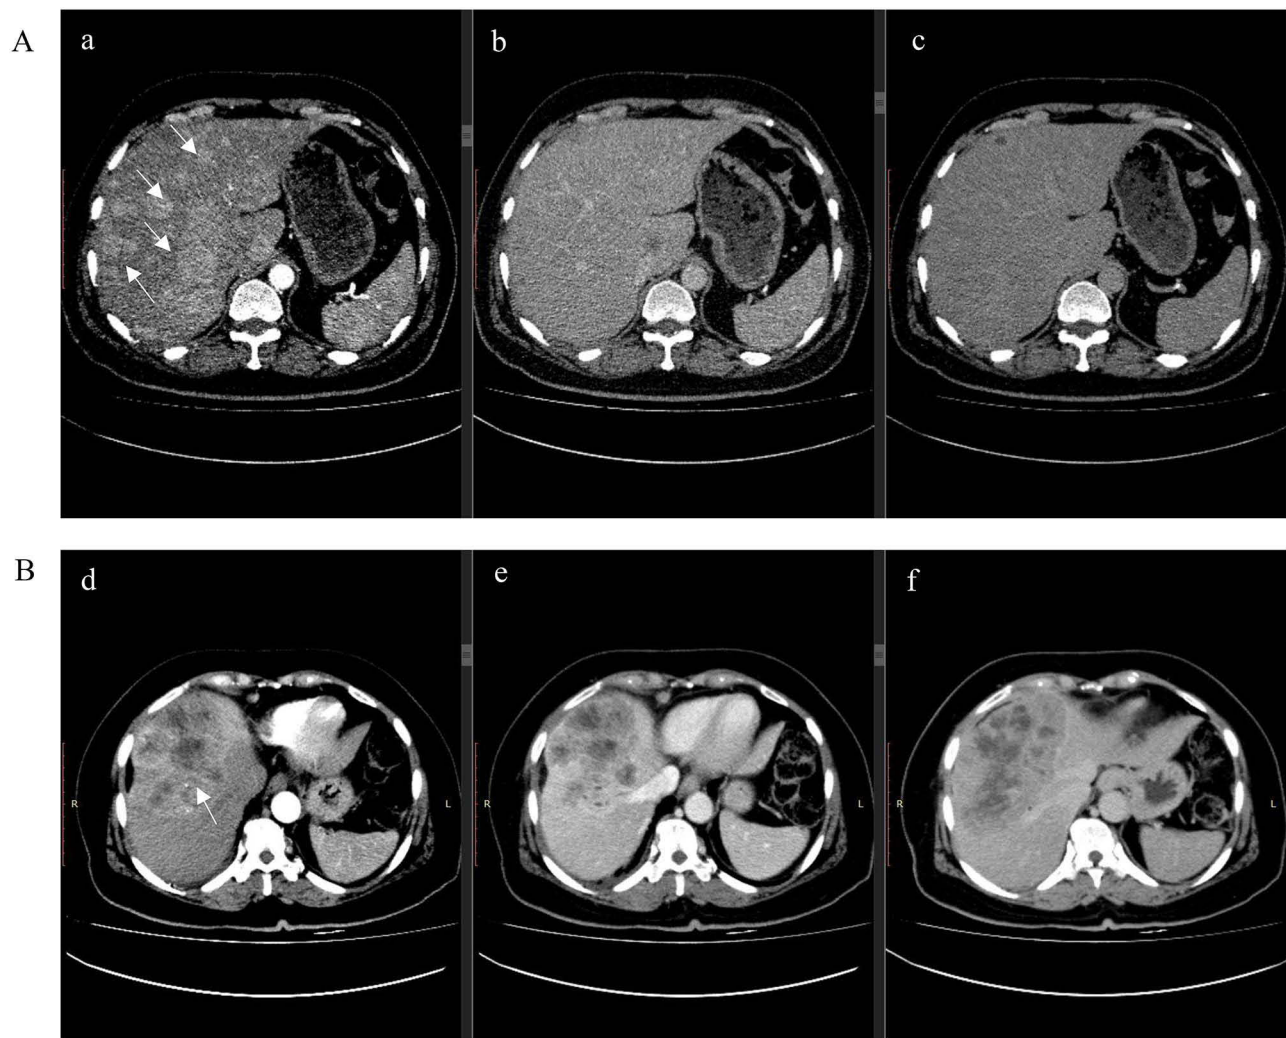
Computed tomography (CT) of Multifocal HCC vs Solitary HCC. (A) CT post-contrast axial a: arterial-phase b: portal venous phase and c: delayed phase images. Innumerable arterially enhancing hepatic lesions of variable sizes are seen demonstrating washout on the portal venous phase, consistent with multifocal HCC. (B) CT post-contrast d: arterial-phase e: portal venous phase and f: delayed phase images, showing relatively circumscribed centrally necrotic mass measuring 8.4×13.9 cm demonstrating peripheral arterial enhancement with venous washout and an enhancing pseudo capsule; this is centered in hepatic segments 4, 5 and 8, and approaches the capsule. Imaging features are compatible with solitary HCC.
